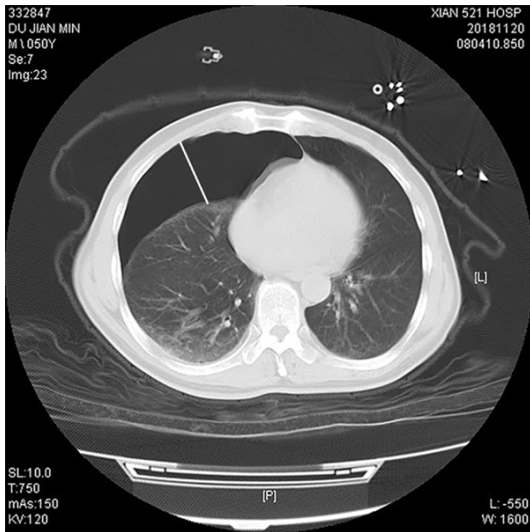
Maximum width (W value) of pneumothorax in cross-sectional CT image (white line).
